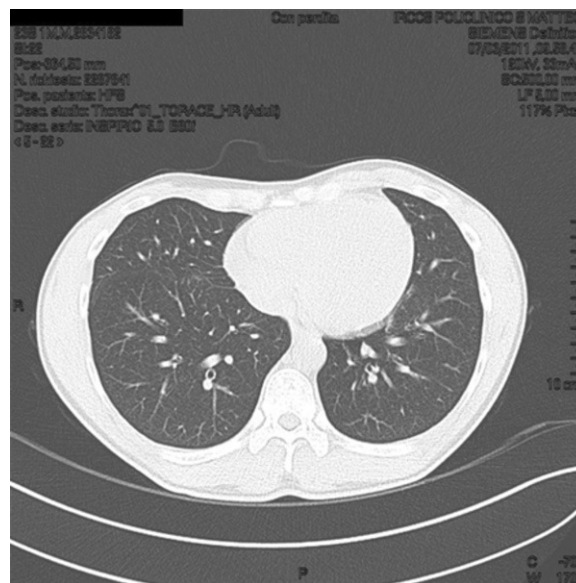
High resolution computed tomography (HRCT) lung at T0 shows in the expiratory phase a marked and uneven alteration in density of both lungs for the coexistence of higher density and hyperlucency areas (part of the mosaic attenuation). These areas represent pulmonary expiratory air trapping secondary to obstruction of the small airways.
